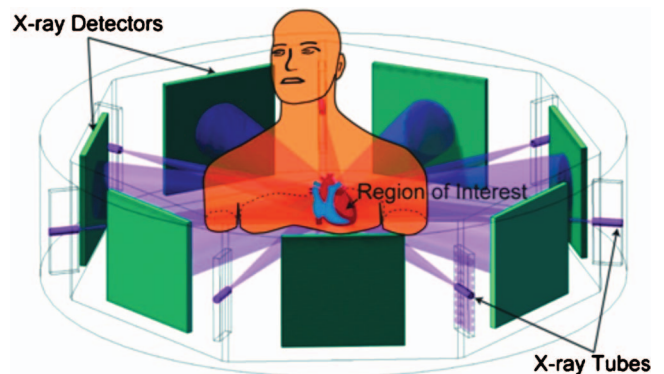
Multisource interior tomography concept—A typical seven-saddle-curve scanning mode for interior cardiac CT to reduce radiation dose and data acquisition time. With the interior tomography approach, the detector size can be much reduced so that more source-detector pairs can be integrated to focus on a ROI for simultaneous collection of multiple local projections.
